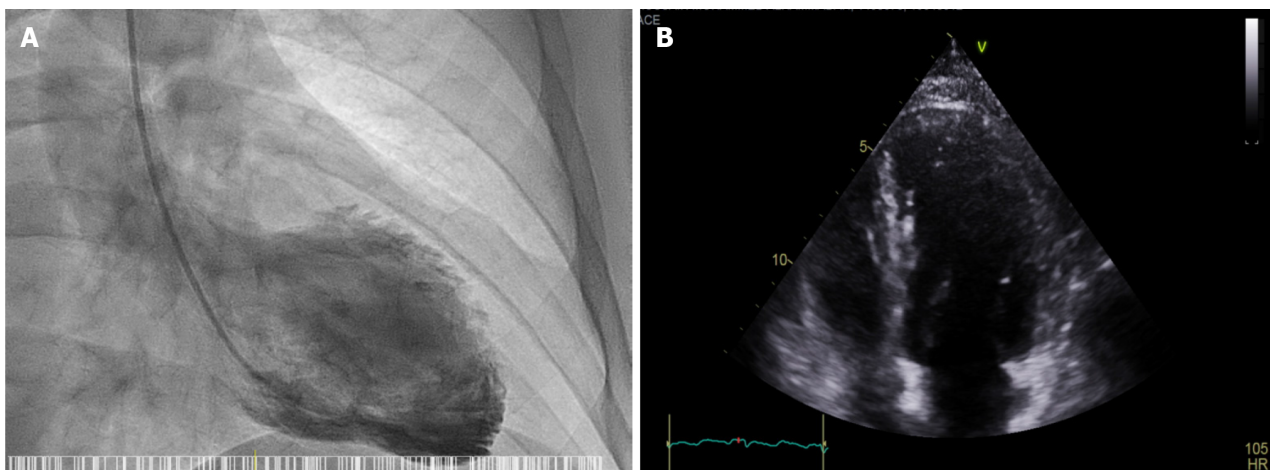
Left Ventricle Angiogram. A: It shows Left Ventricle Angiogram showing apical ballooning; B: Echocardiogram shows Apical ballooning.
